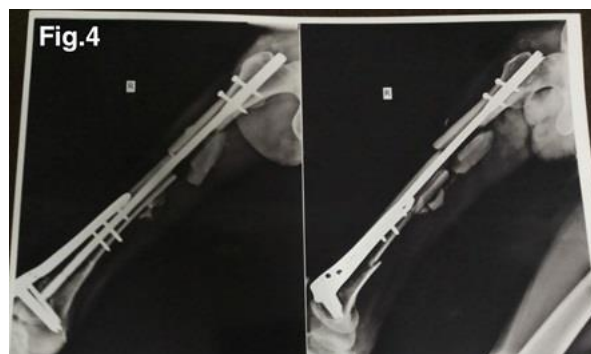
depicts an X-ray taken on October 27, 2020, following Bone Grafting.
